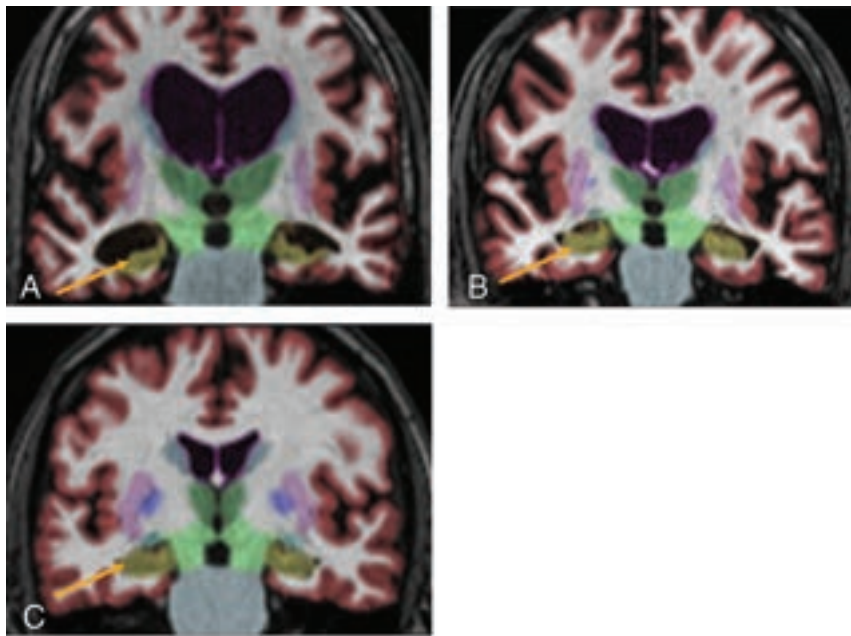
Coronal T1 noncontrast MR images with automated segmentation overlay obtained from NeuroQuant showing hippocampal volumes (yellow arrow) for patients with AD (A), mild cognitive impairment (B), and SCD (C). Note the marked hippocampal atrophy for AD compared with MCI and SCD.
